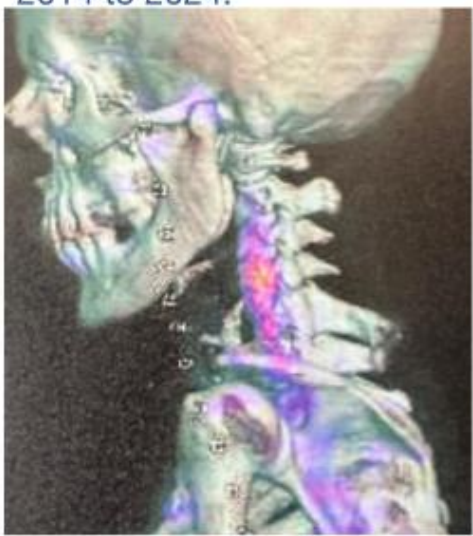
3D fused single photon emission CT demonstrate increased radiotracer uptake in within bilateral C3-4 to C6-7 facet joints compatible with degenerative facet arthropathy.
